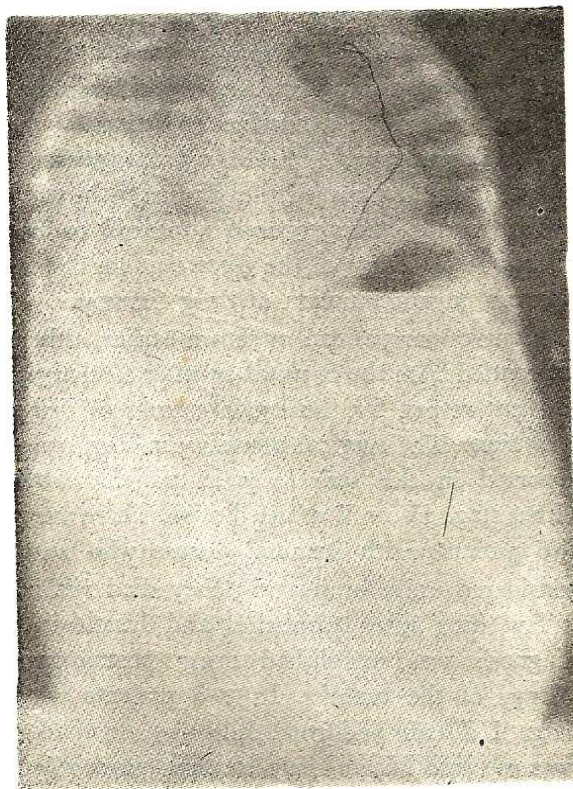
Chest X-ray showing 'cannon ball' metastasis in the right lung in a child with Wilms' tumour.
